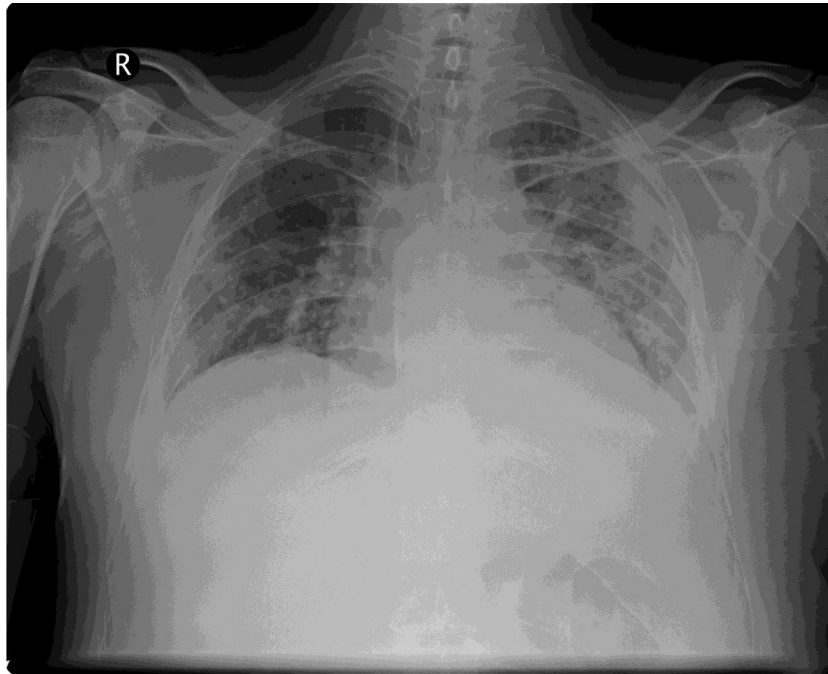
Chest radiograph of *L. donaldsonii* pneumonia in a 35-year-old man with a hematopoietic stem cell transplant.
